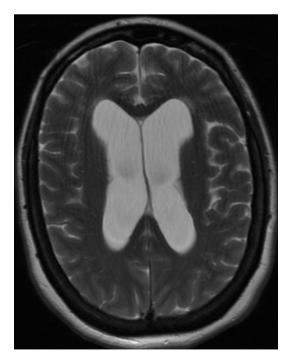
Axial T2 MRI of the brain without contrast shows ventricular enlargement consistent with hydrocephalus (August 2020).
